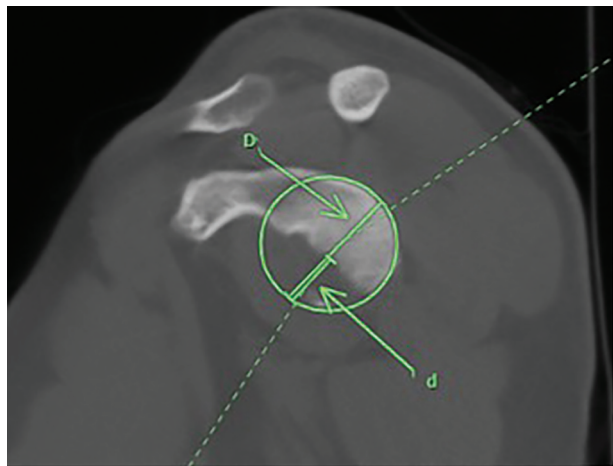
Measurement of the glenoid track using the best-fit circle method; with D being the diameter of the glenoid and d representing the amount of glenoid bone loss. These measurements are made using sagittal computed tomography images.
